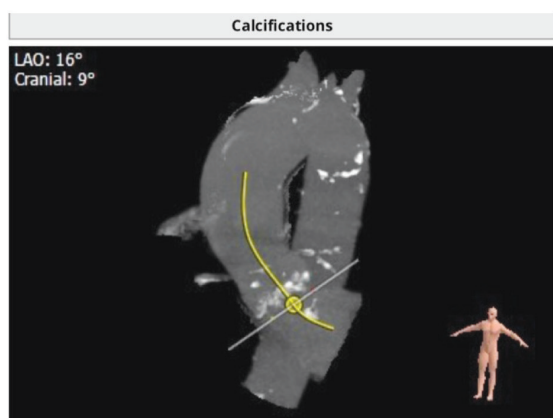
CT, aorta, patient No 2
